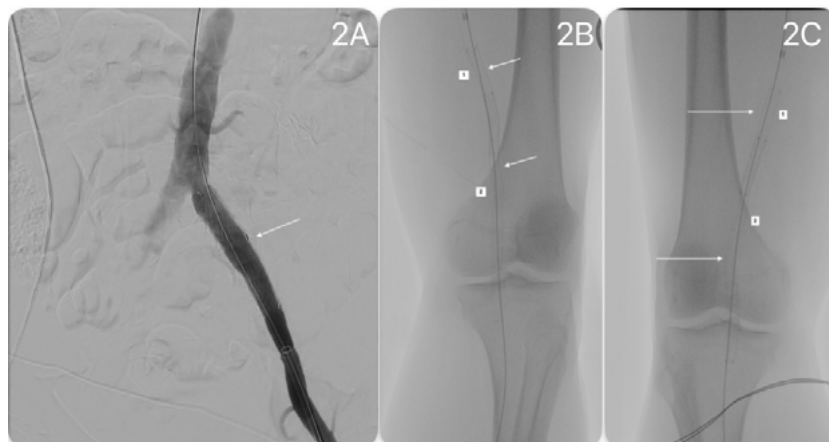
A. Intraoperative angiography showing successful exclusion of the left common iliac artery aneurysm with the deployment of an iliac limb extension (white arrow) B. Intraoperative x-ray indicating successful deployment of the 2 Viabahn® stent-grafts on the left side (1 for the proximal/8x75mm and 2 for the distal/7x150mm stents), which were deployed from distal to proximal. C. Same for the right side.
